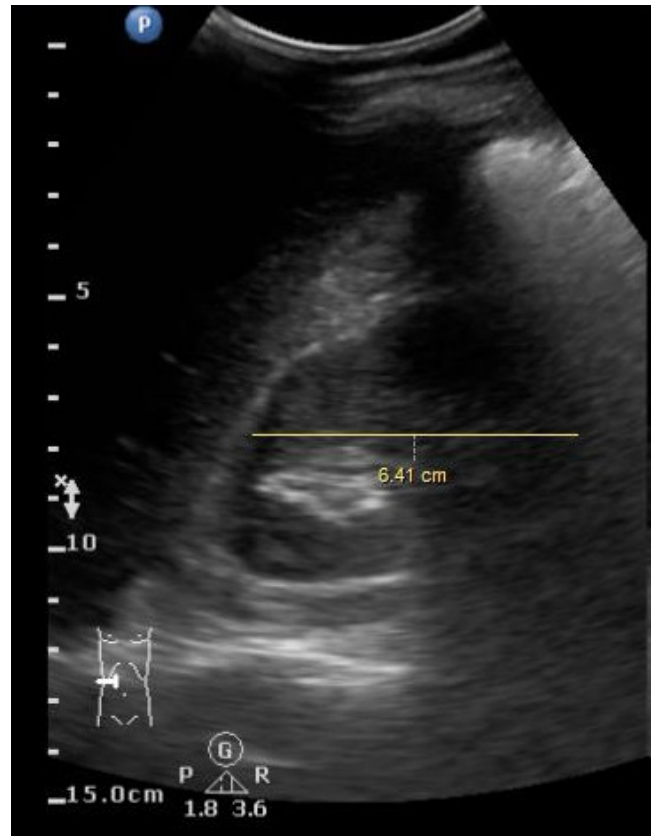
Sonography transverse scan of the right kidney shows renal width measurement
